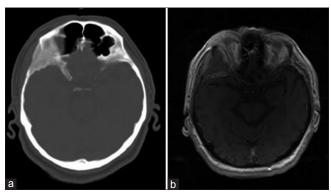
The mass in the right temporal bone, orbita, and sphenoid wings in the patient's bone window computed tomography (a) and the mass lesion which includes peripheral contrast uptake and spreads to lateral rectus in superolateral region of the right orbit in the patient's contrast-enhanced brain magnetic resonance imaging (b)
